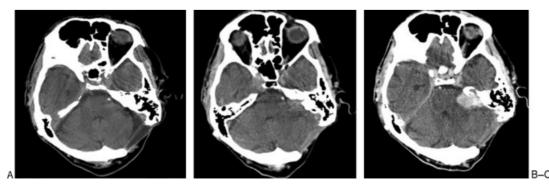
Serial CT scans of the patient. (A) December 2006 prior to pacemaker insertion. (B) October 2007, noncontrast. (C) October 2007, with contrast.
